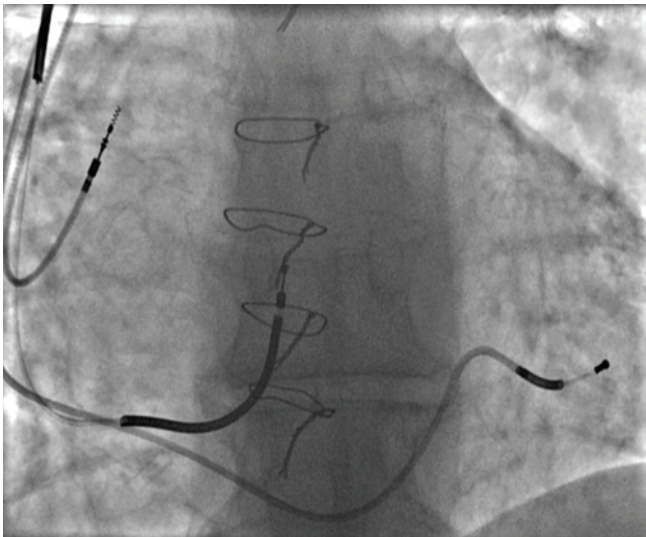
Post implant x-ray showing the appropriate lead location
